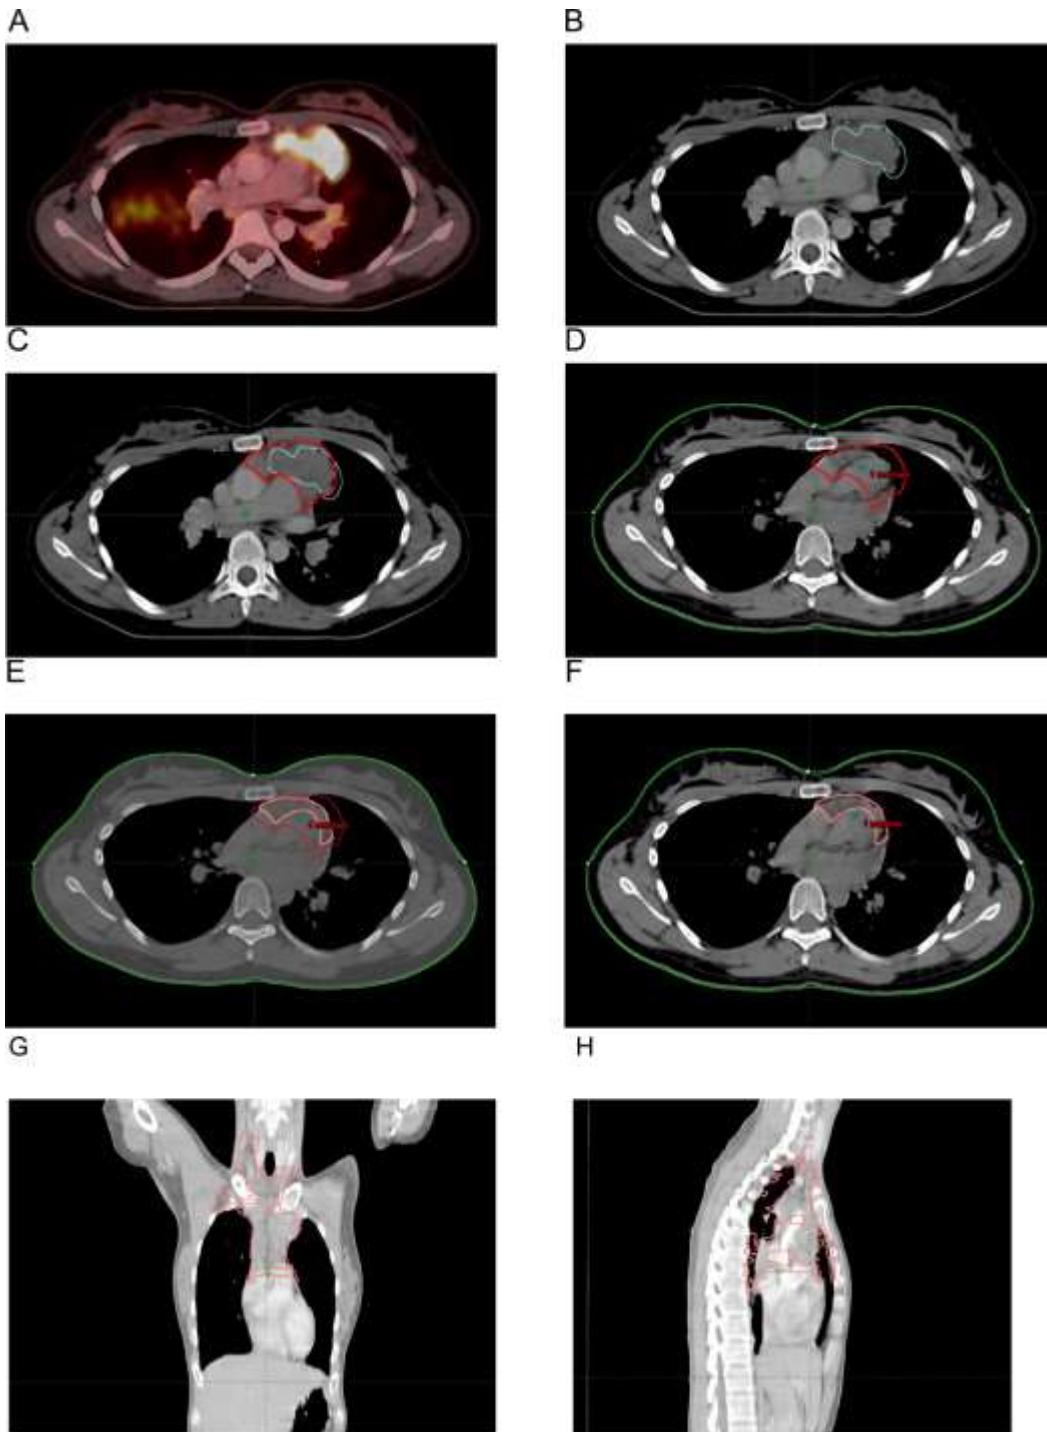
(A-H) Patient with diffuse large B-cell lymphoma CS 2A with mediastinal involvement. (A) Prechemotherapy positron emission tomography (PET)/CT scan showing the initially PET-positive volume. (B) Prechemotherapy CT part of the PET/CT-scan with the contoured initially PET-positive involved lymphoma volume in blue. (C) Prechemotherapy CT scan with the contoured initially involved lymphoma volume (GTVCT) in red, including both PET-positive and PET-negative parts of the lymphoma. (D) Postchemotherapy planning CT scan with the prechemotherapy GTVCT transferred by image fusion. (E) Postchemotherapy planning CT scan. The clinical target volume in pink is the tissue volume that contained lymphoma initially. It is created by modifying the GTVCT to take into account tumor shrinkage and other anatomic changes, allowing for uncertainties in contouring and differences in position. (F) Postchemotherapy planning CT scan with the final clinical target volume, which encompasses all of the initial lymphoma volume while still respecting normal structures that were never involved by lymphoma. (G) Coronal image. (H) Sagittal image.
